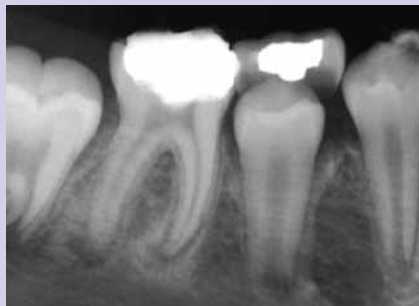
Radiograph of periapical radiolucency.
